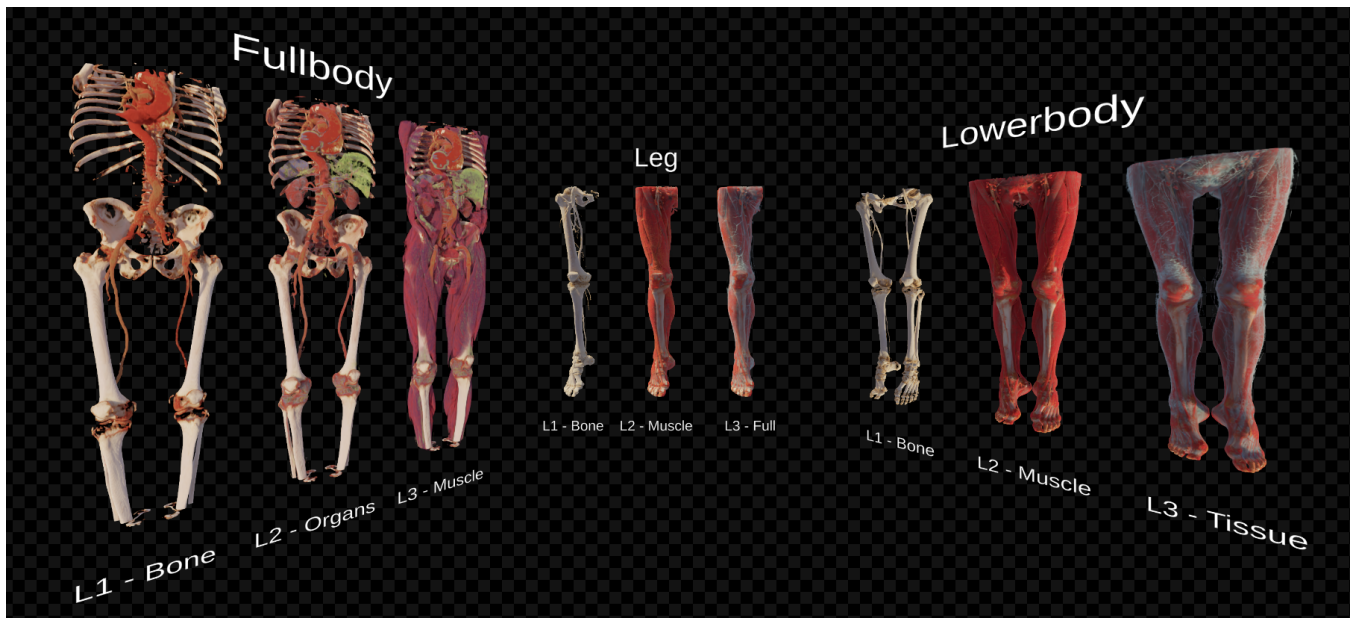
Overview of all CT data scenes used in our anatomy dataset, as seen from within the game engine.
